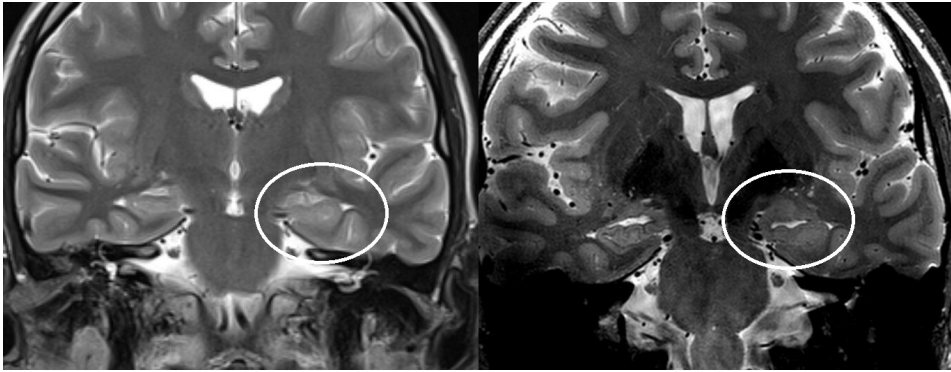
Hippocampal sclerosis demonstrated on coronal T2-weighted 3T MRI (left) 7T MRI (right). Hippocampal volume loss and increased signal intensity are visible on both images, with improved lesion conspicuity and delineation on the 7T image.
